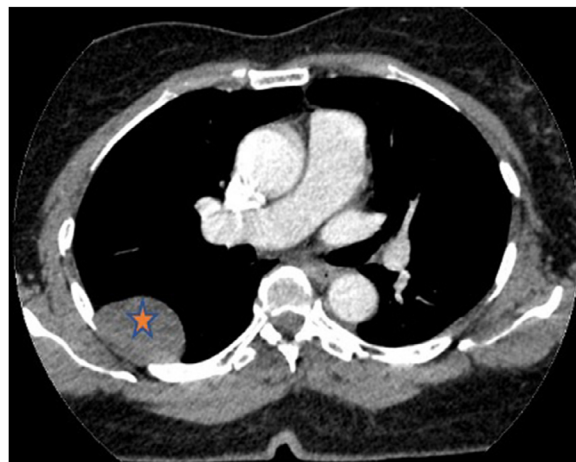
Axial view chest computed tomography with a mediastinal window and contrast injection showing a circumscribed, well-defined pleural-based mass (asterisk).
